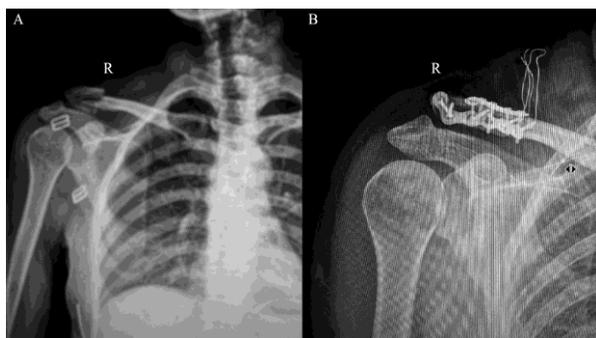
Preoperative and postoperative X-ray films. (A) Preoperative X-ray film; (B) Postoperative X-ray film
